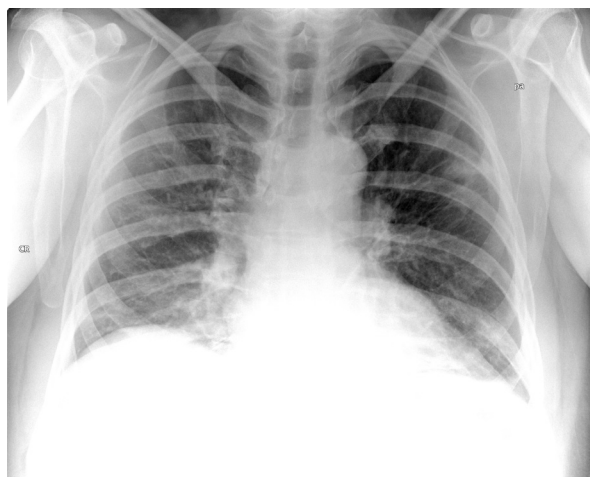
Chest X-ray upon discharge from the negative pressure room (day 8)
